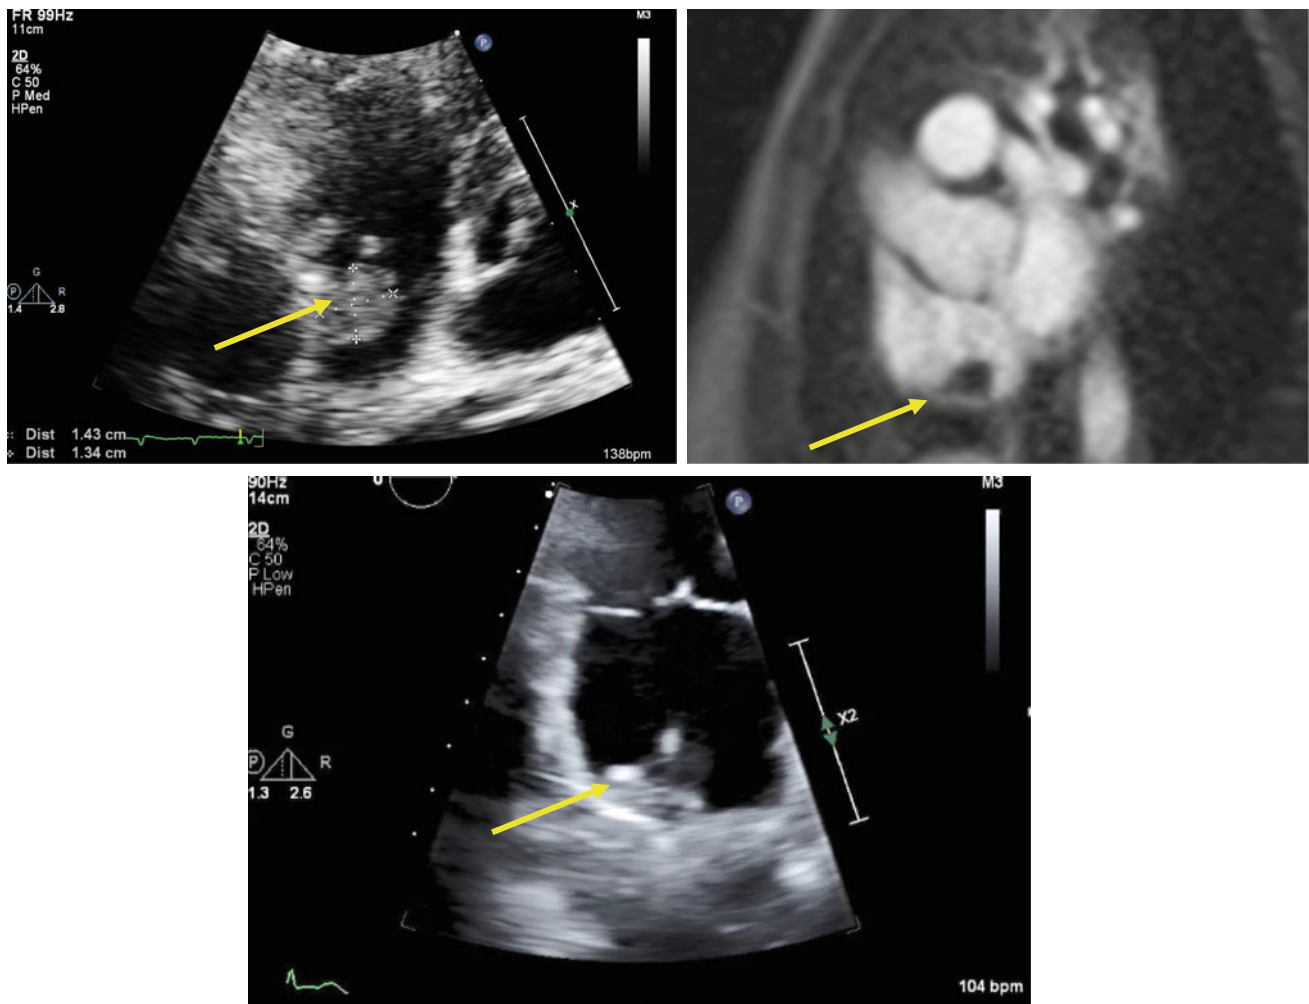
Top left: 2-D echocardiogram shows rounded right atrial mass next to port catheter seen, measuring 1.43×1.34 cm in still image. Top right: MRI Short Axis Perfusion sequence during
